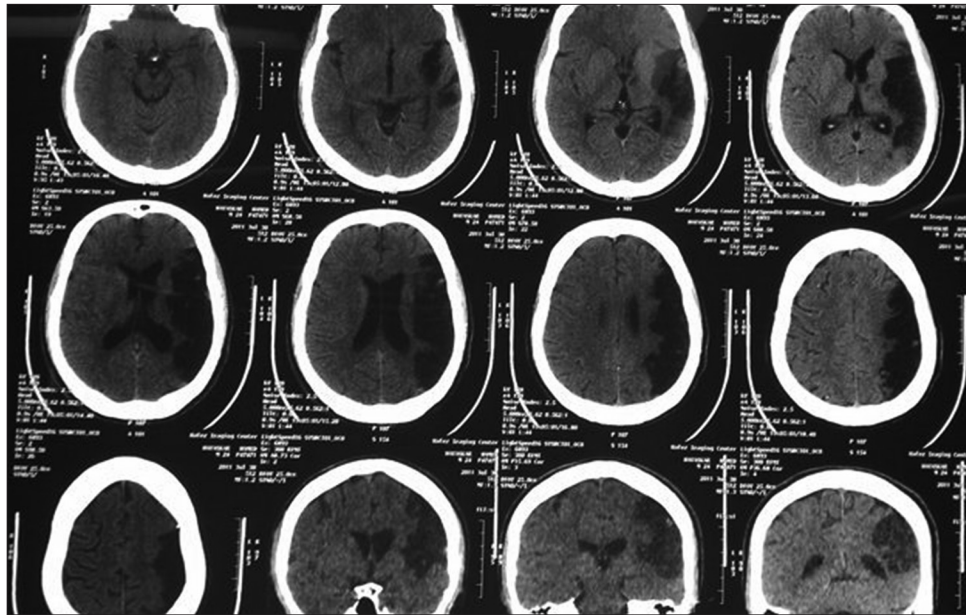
Patient's computed tomography scan in 2 months after admission
